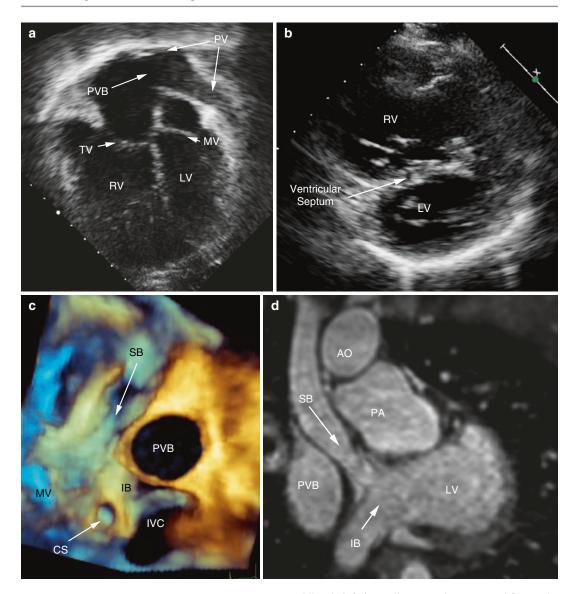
Transposition of the great arteries treated by redirection of atrial flow (Senning operation). (a) Apical four chamber view showing the pulmonary veins being diverted through the pulmonary venous baffle towards the tricuspid valve and systemic RV. The RV is larger than the LV, the opposite of the normal appearance. (b) Short axis view showing the large RV and flattened ventricular septum following the Senning operation. The RV is at systemic pressure and the LV at lower (pulmonary artery) pressure, accounting for the flattening of the ventricular septum. (c) Three-dimensional transoesophageal echocardiogram showing the systemic venous baffles viewed from the left side. The superior baffle is seen passing
